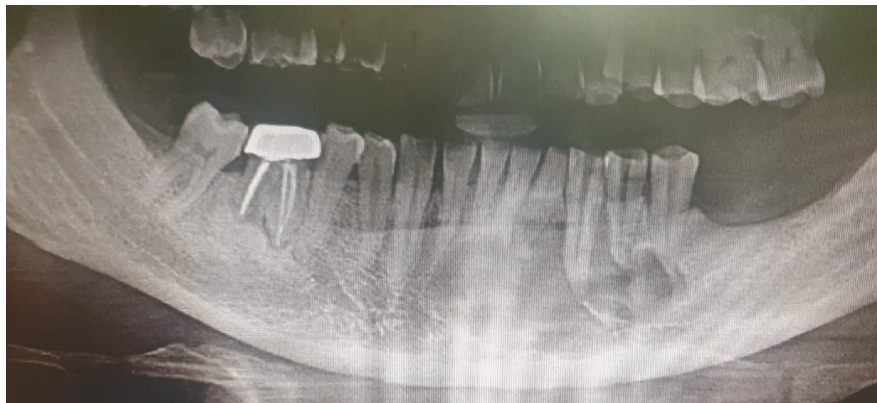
Orthopantomogram revealed a well-defined multi locular radiolucent lesion involving 35 to 43 teeth region.
